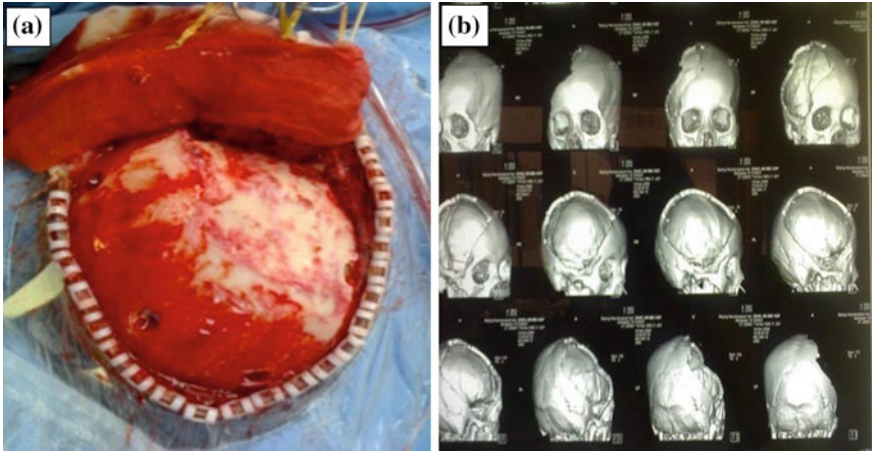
Cranial window: the average size is $12 \times 15 \text{ cm}^2$. a Patient; b CT
